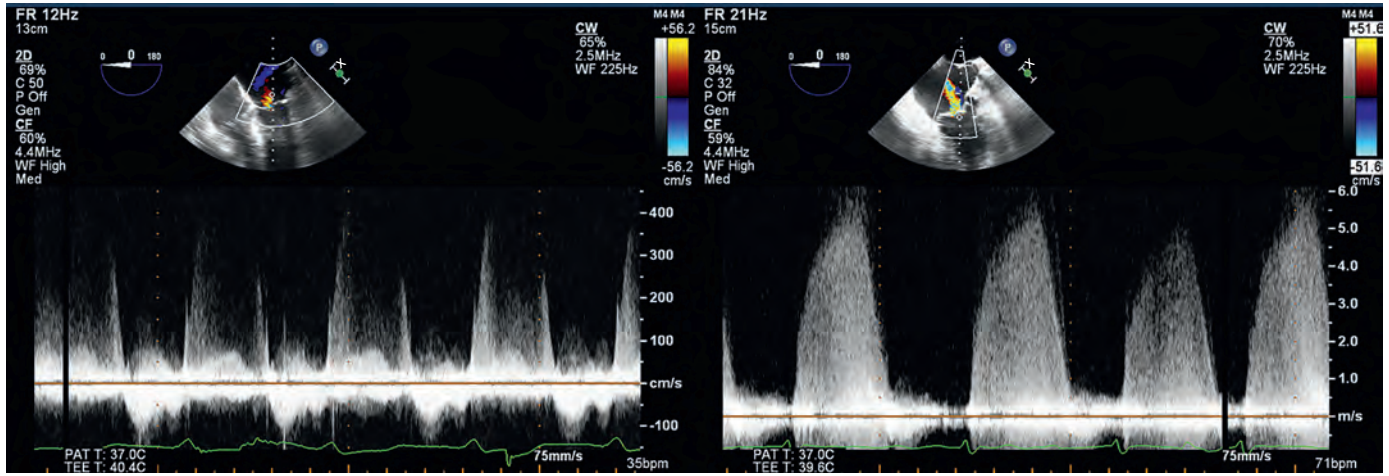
Doppler spectrum with mitral regurgitation. (Left) Mild degree of mitral regurgitation results in a lighter incomplete Doppler spectrum when the regurgitant flow is visualized. (Right) With severe regurgitation, the Doppler spectrum becomes more solid and more intense in character.
